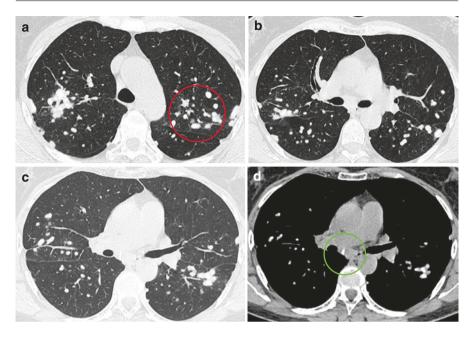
(a) HRCT of the lungs: multiple nodules in the perilymphatic distribution. (b) HRCT of the lungs: multiple nodules in the perilymphatic distribution, mainly on fissures. (c) HRCT of the lungs: multiple nodules in perilymphatic distribution, and calcified mediastinal nodes. (d) HRCT of the lungs (mediastinal window): multiple nodules with calcifications, and calcified mediastinal nodes
